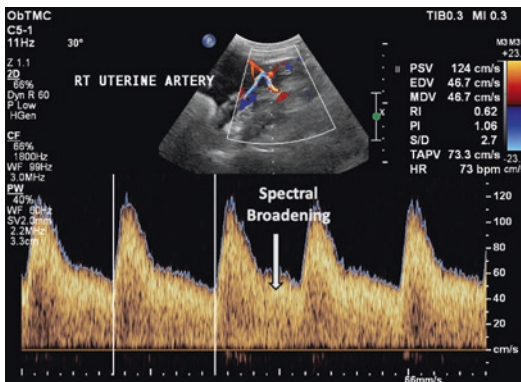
Spectral broadening. Top: Flow-guided placement of the Doppler sample volume in the uterine artery. Note the spectral broadening of the waveform
